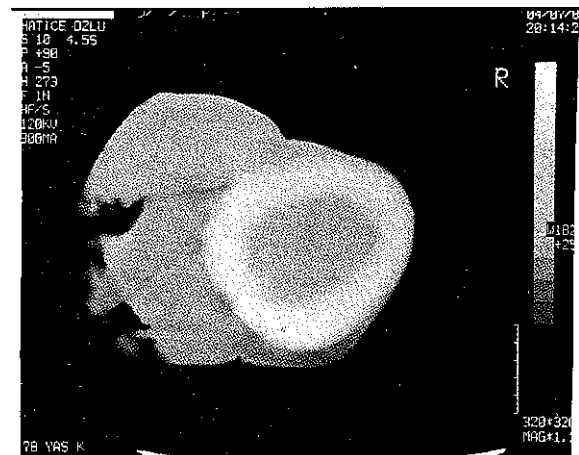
Another CT section from the same patient showing the ulcerations on tumor surface, periosteal irregularities, and cortical thickening in the skull.
